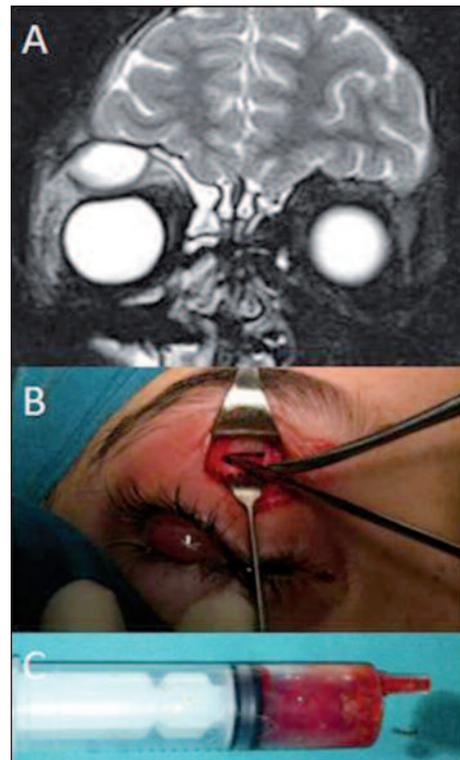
A. Coronal T2 weighted Magnetic Resonance Image shows subperiosteal hyperintense cystic lesion of orbital roof associated with focal area of mass effect and globe distortion inferiorly, confirming abscess. Adjacent ethmoid sinus is opacified with fluid intensity signal. B. Peroperatively, dissection of the periosteum and drainage of the abscess. C. Collected samples (Case 2).
